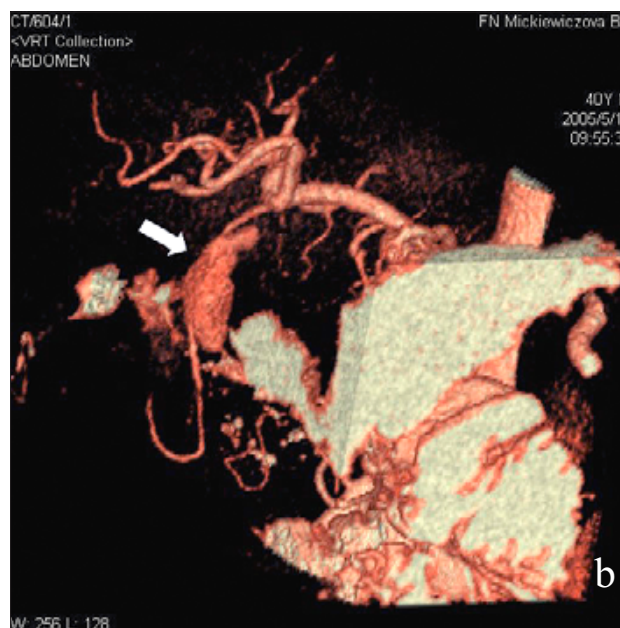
a) The contrast-enhanced CT shows a pseudoaneurysm localized in the area of the head of pancreas. b) The 3D reconstruction of CT angiography revealed pseudoaneurysm of the gastroduodenal artery. Marked outpouching represents the contrast in a part of pseudoaneurysm, the rest of the vascular lesion (non seen) is filled with thrombi.
